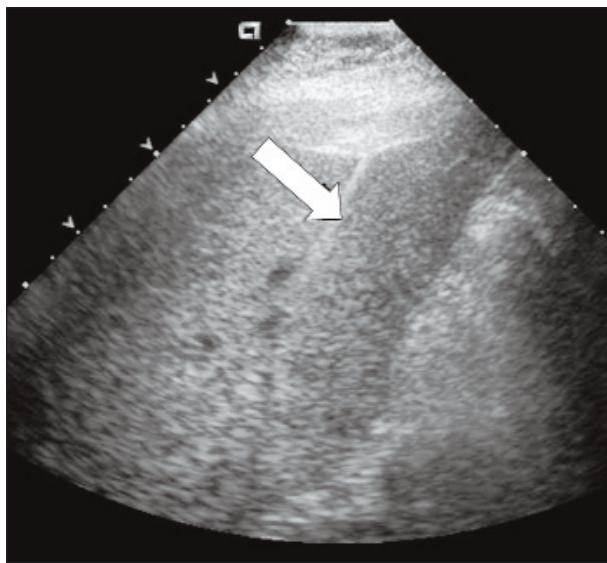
The PV (arrow) was seen under the ultrasound guidance.
